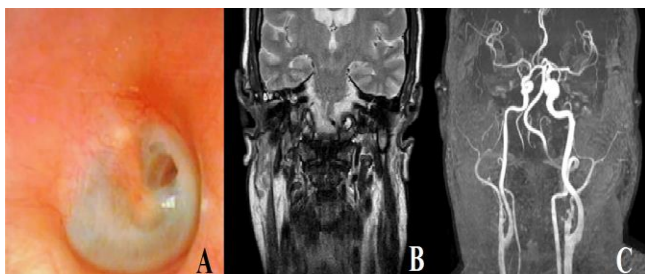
A. Right otoscopy, sequel perforation; B. MRI with contrast agent IV. Coronal plane: Reduction in volume and extent of pathologic tissue at intense enhancement, with right oto-mastoid epicentre; C. Magnetic Resonance Angiography. Transversal plane: Partial restoration of the vessel diameter of the intracranial tract of the right internal carotid artery.
